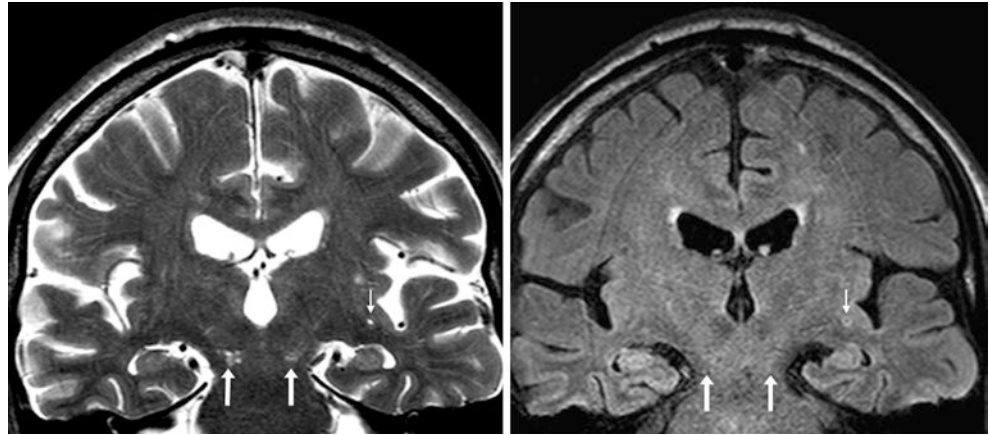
A 67 year old had dilated PVSs within the midbrain (*arrows*) on 3T MRI coronal T2WI (*left two images*), which suppress similar to CSF on FLAIR (*right*). Dilated PVSs are also noted on T2WI throughout the subcortical white matter and inferior putamina bilaterally (*tiny arrows*). This MRI was interpreted as normal for the patient's age
